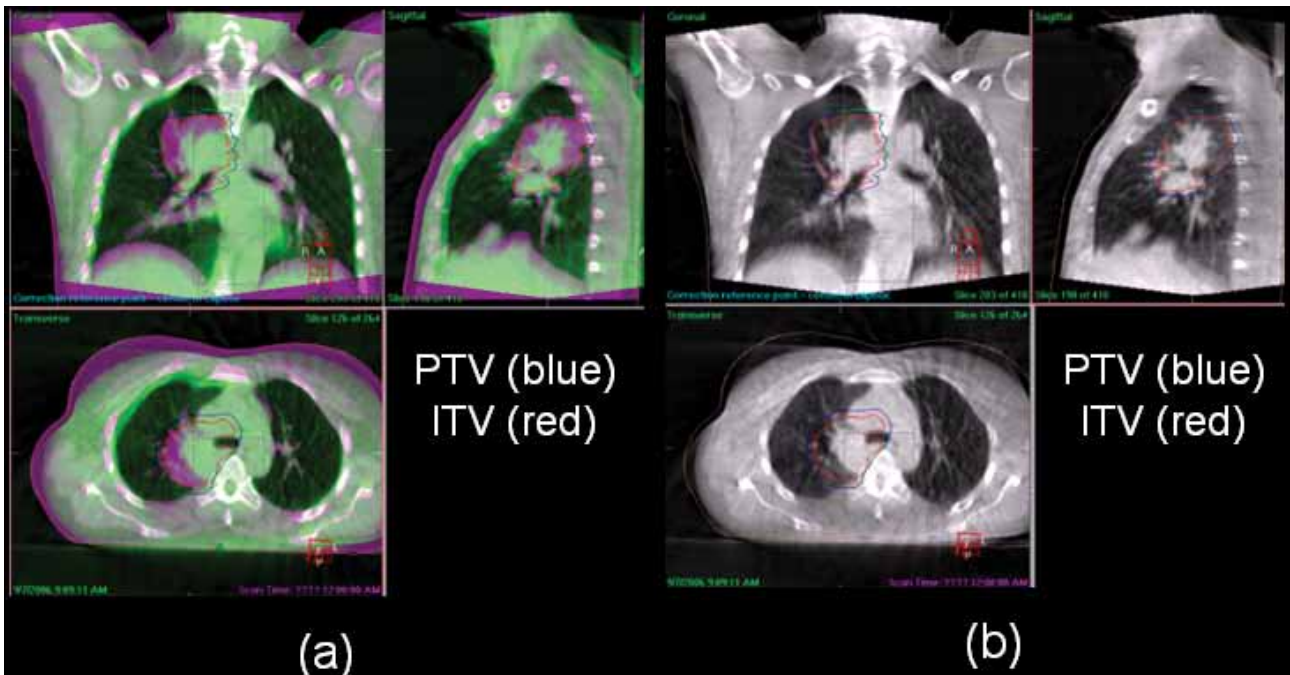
tumor shrinkage shown in the 18th fraction: (a) VolumeView registered (shown in green) with the reference CT (shown in purple) for on-line treatment correction. (b) only the VolumeView is shown after registration with the reference CT.
